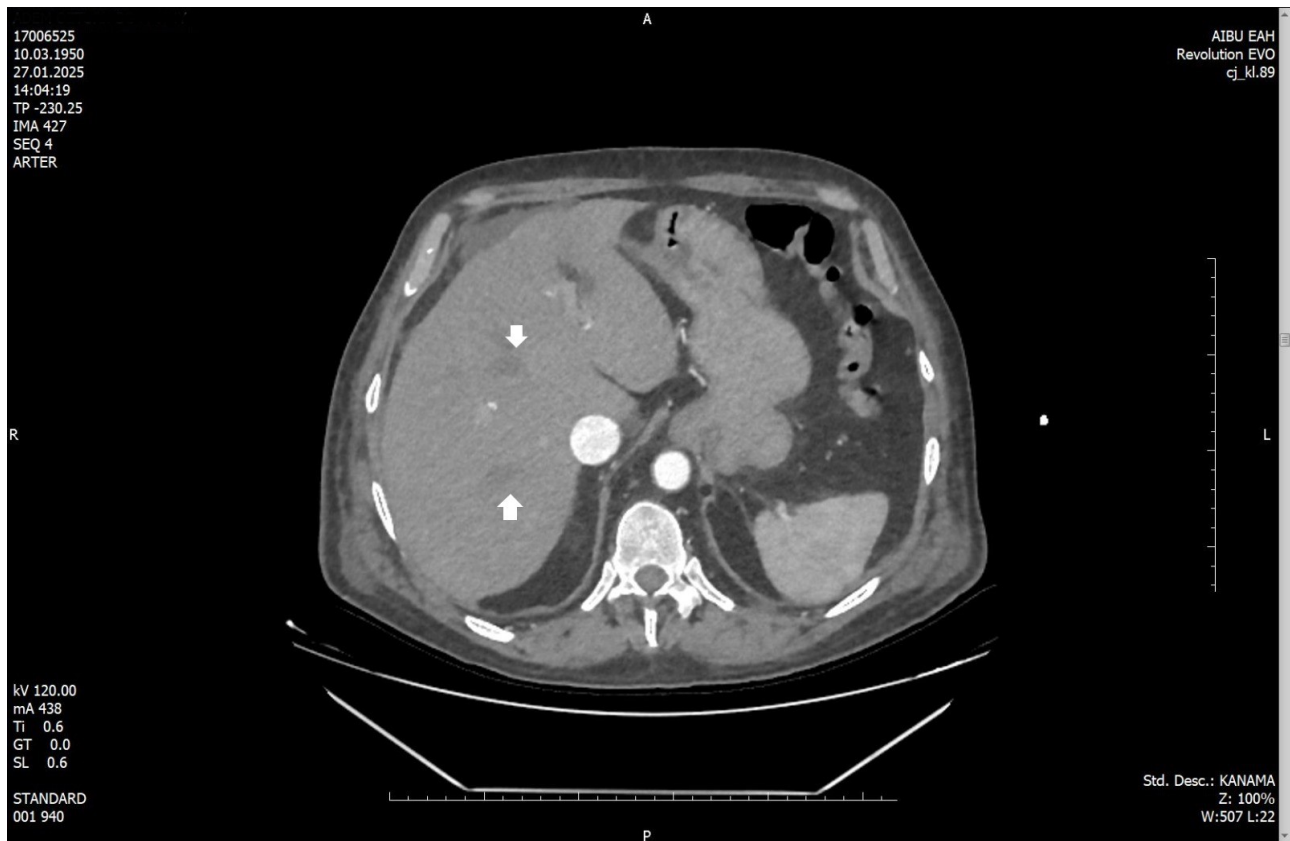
Hepatic metastases in CT image of the patient. Hepatic metastases (White arrows).
